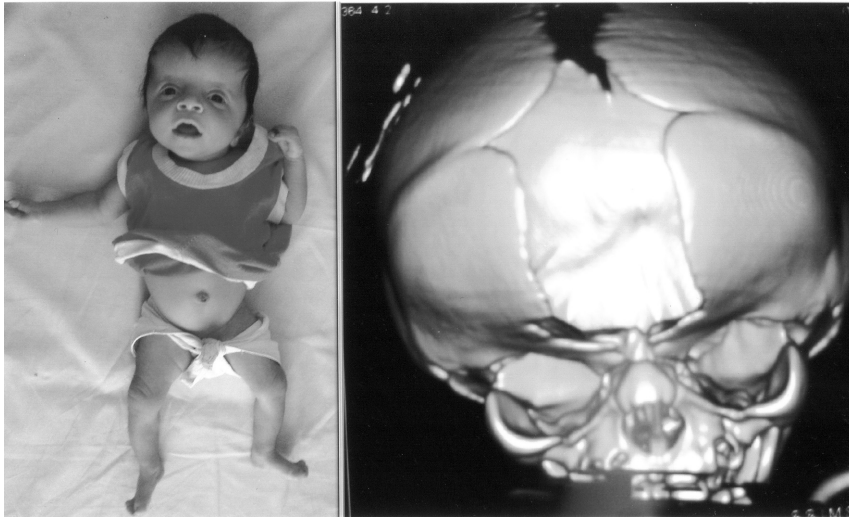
Apert syndrome the prototype of craniosynostosis syndrome appreciate the high full forehead, hypertelorism and downslanting palpebral fissures. Limbs show varying degress of syndactyly. CT reconstruction of the skull vault shows bilateral coronal suture synostosis.
